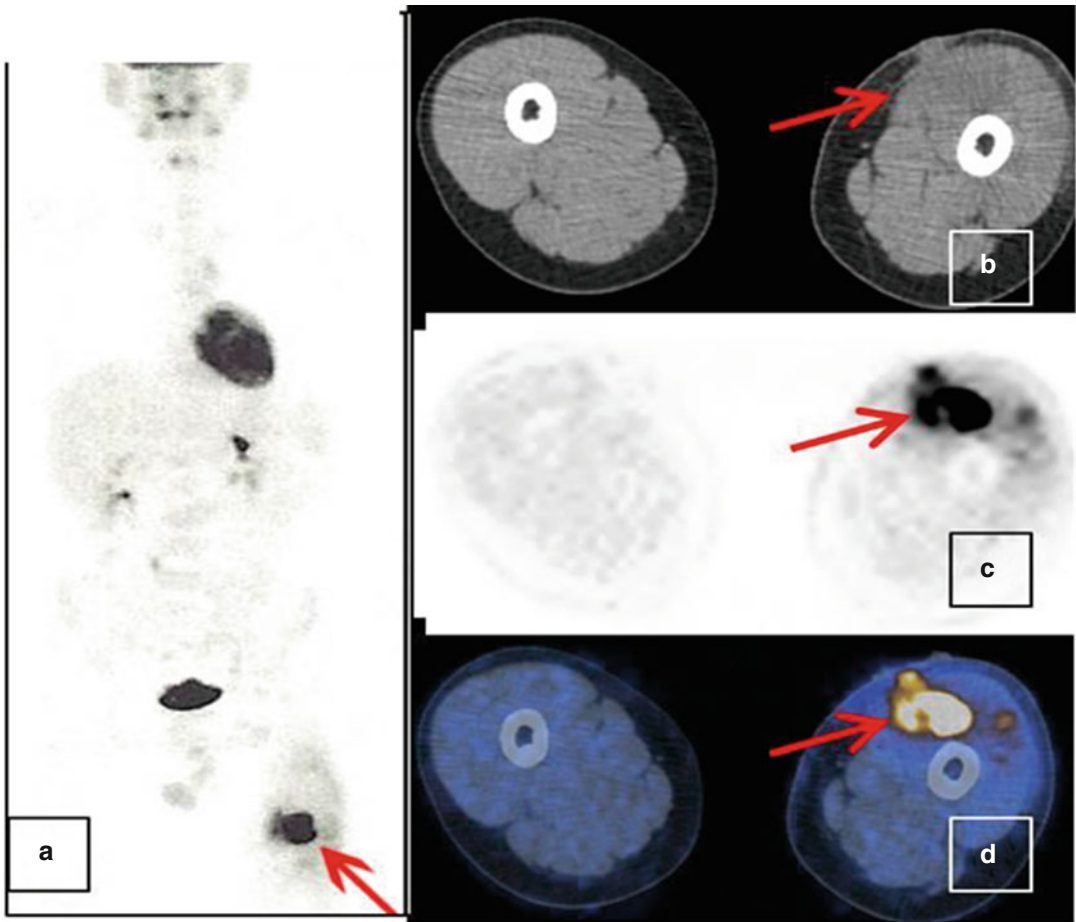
(a) FDG-MIP imaging, (b) CT imaging, (c) FDG-PET imaging, (d) fused FDG-PET/CT imaging. Increased FDG uptake at the left thigh is observed
